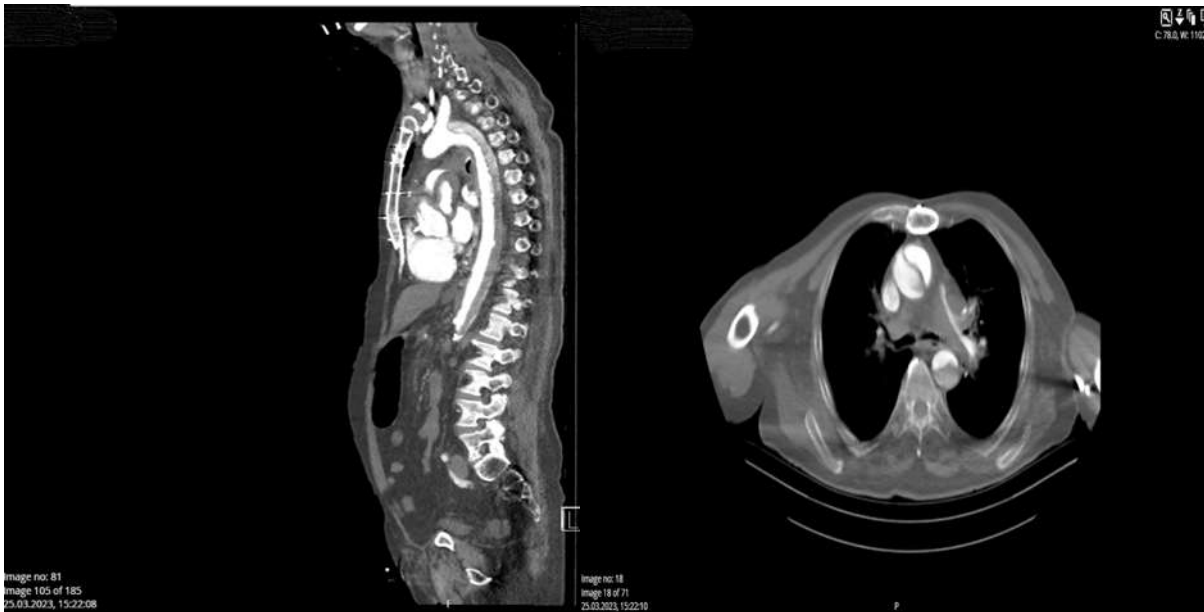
Aortic dissection at CT angiography.
